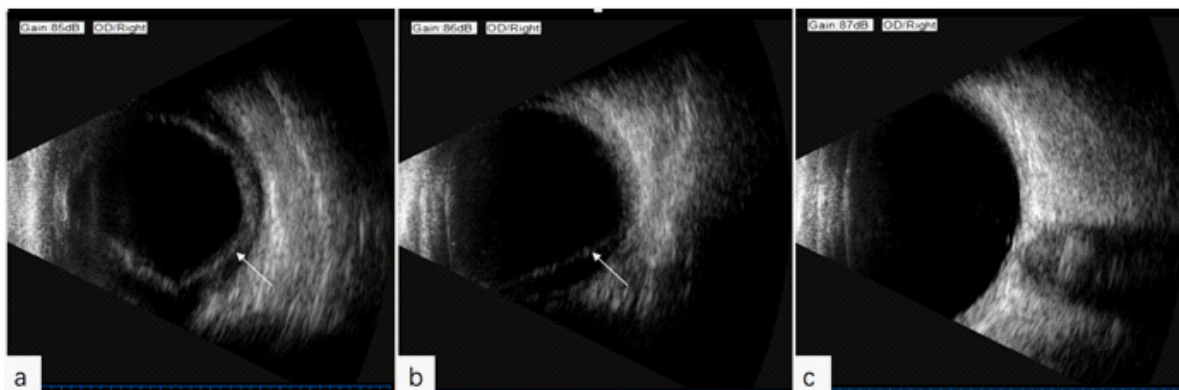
Choroidal detachment (arrow) on B-mode ultrasonography. At onset (a); No significant improvement after methylprednisolone 80 mg/d for 7 days (b); Completely recovered after additional par ocular injection of fluoxyprednisolone 40 mg for each eye (c).
